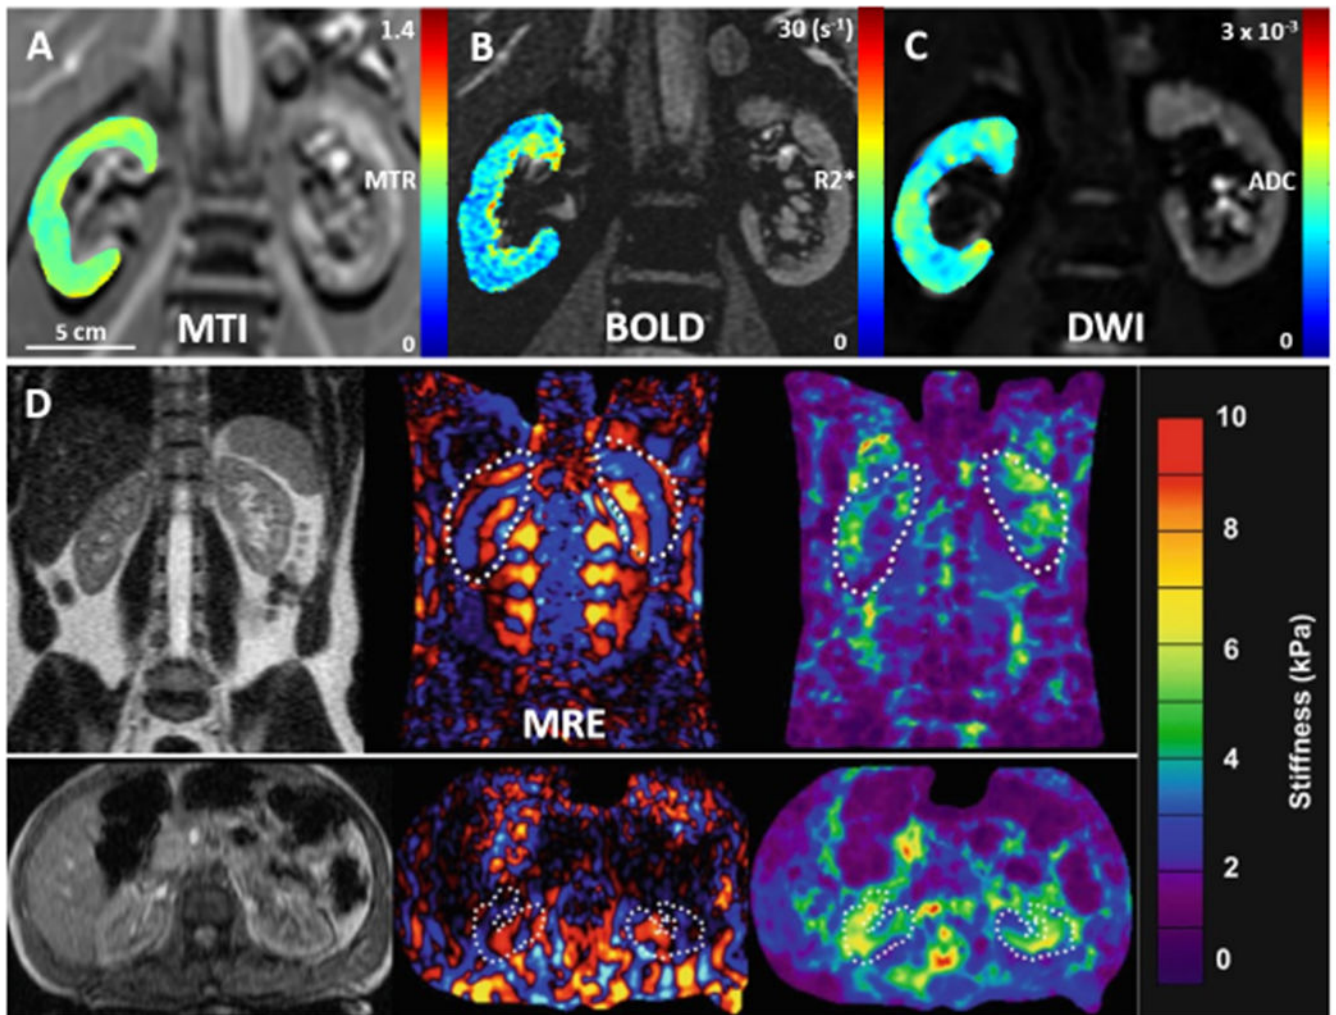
Multi-parametric MRI sequences in the human kidney.
